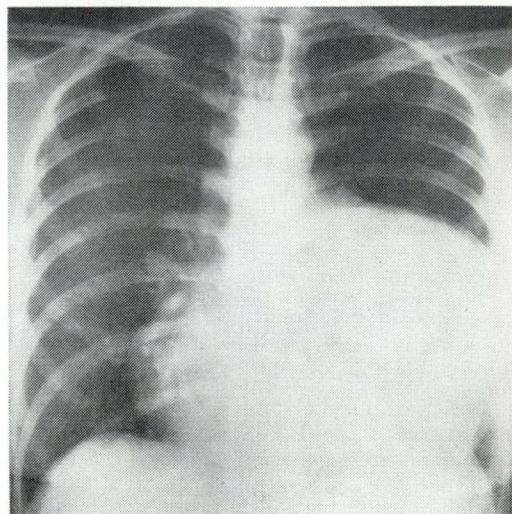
Case 2—bronchogenic cyst. Preoperative chest radiograph.
